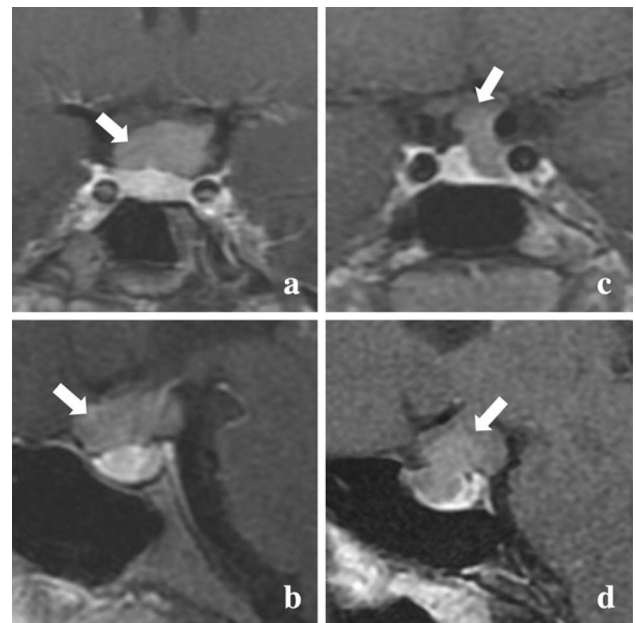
MRI presentations of Patients 8 (a, b) and 9 (c, d). White arrows show suspicious tumors
